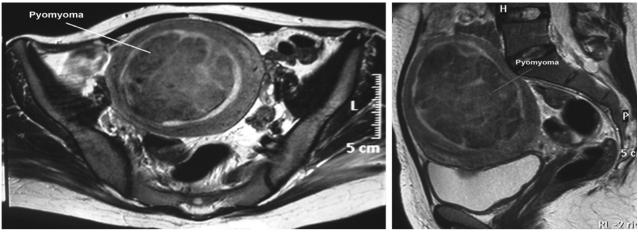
Magnetic resonance imaging revealed necrotic foci inside the leiomyoma (a, axial view; b, lateral view).
